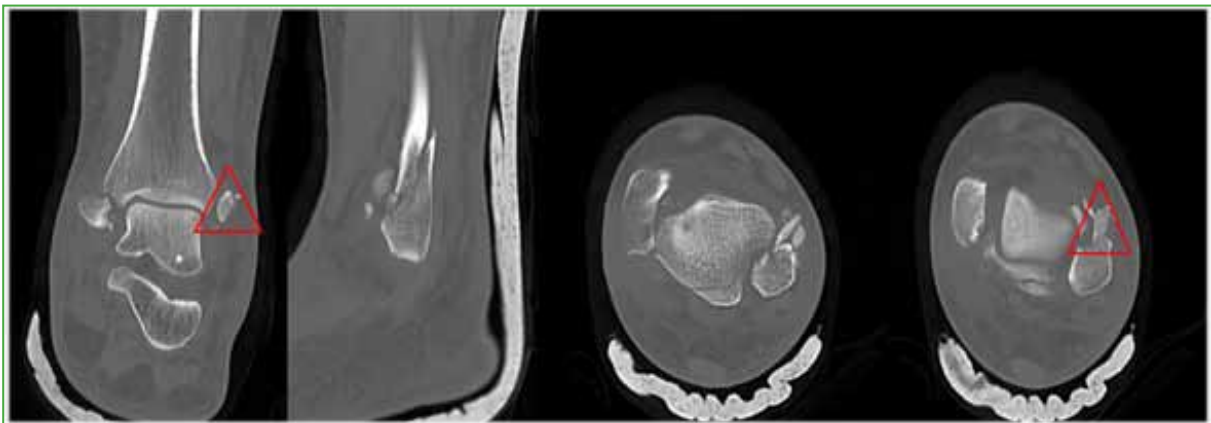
Initial computed tomography of the left ankle. Wagstaffe-Le Fort fragment, increased anterior and sagittal translation of the distal fibula in the axial section.
